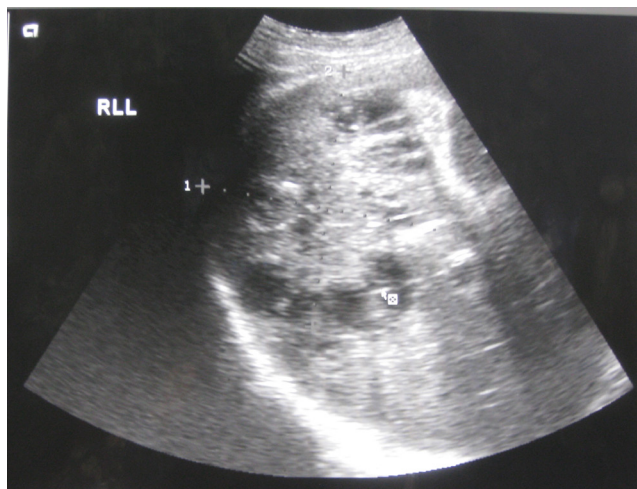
Ultrasound of the right hepatic abscess
